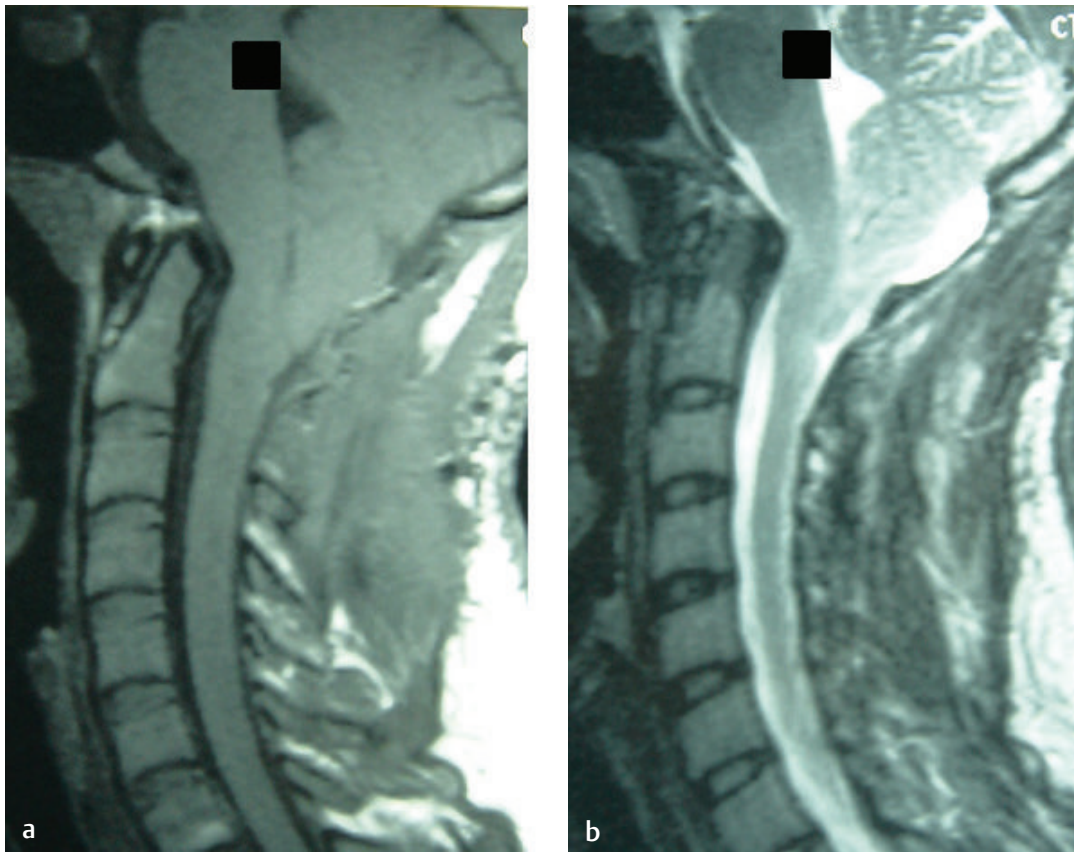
These sagittal (a) T1-weighted and (b) T2-weighted images of a patient with a type-I Chiari malformation who has undergone a suboccipital decompression procedure.
